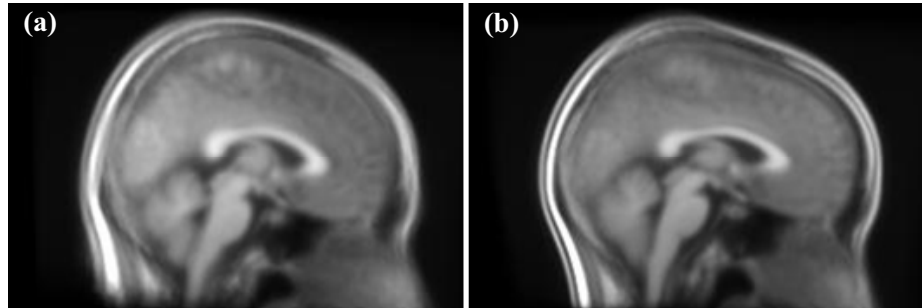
Regularization degree of non-rigid registration influences the sharpness of mean alignment results. Generally, highly regularized registrations result in sharp mean image, (b), compared to that of less regularized alignments, (a). SPM2 was utilized in this example for the non-rigid registrations of 57 T1-weighted MR images.
